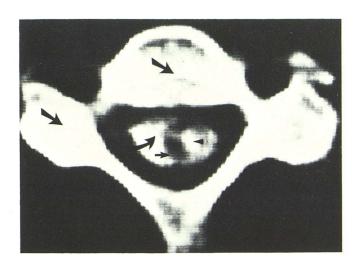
CT of spinal cord with metrizamide C5. Vertebral elements (arrow); metrizamide (curved arrow), average CT number 240; Spinal cord (small arrow), average CT number 30; Optimum window center setting (level) is 135 (mean between 240 and 30). Study shows cyst within cord filled with metrizamide (arrowhead). Window width of 200 chosen for aesthetics.
